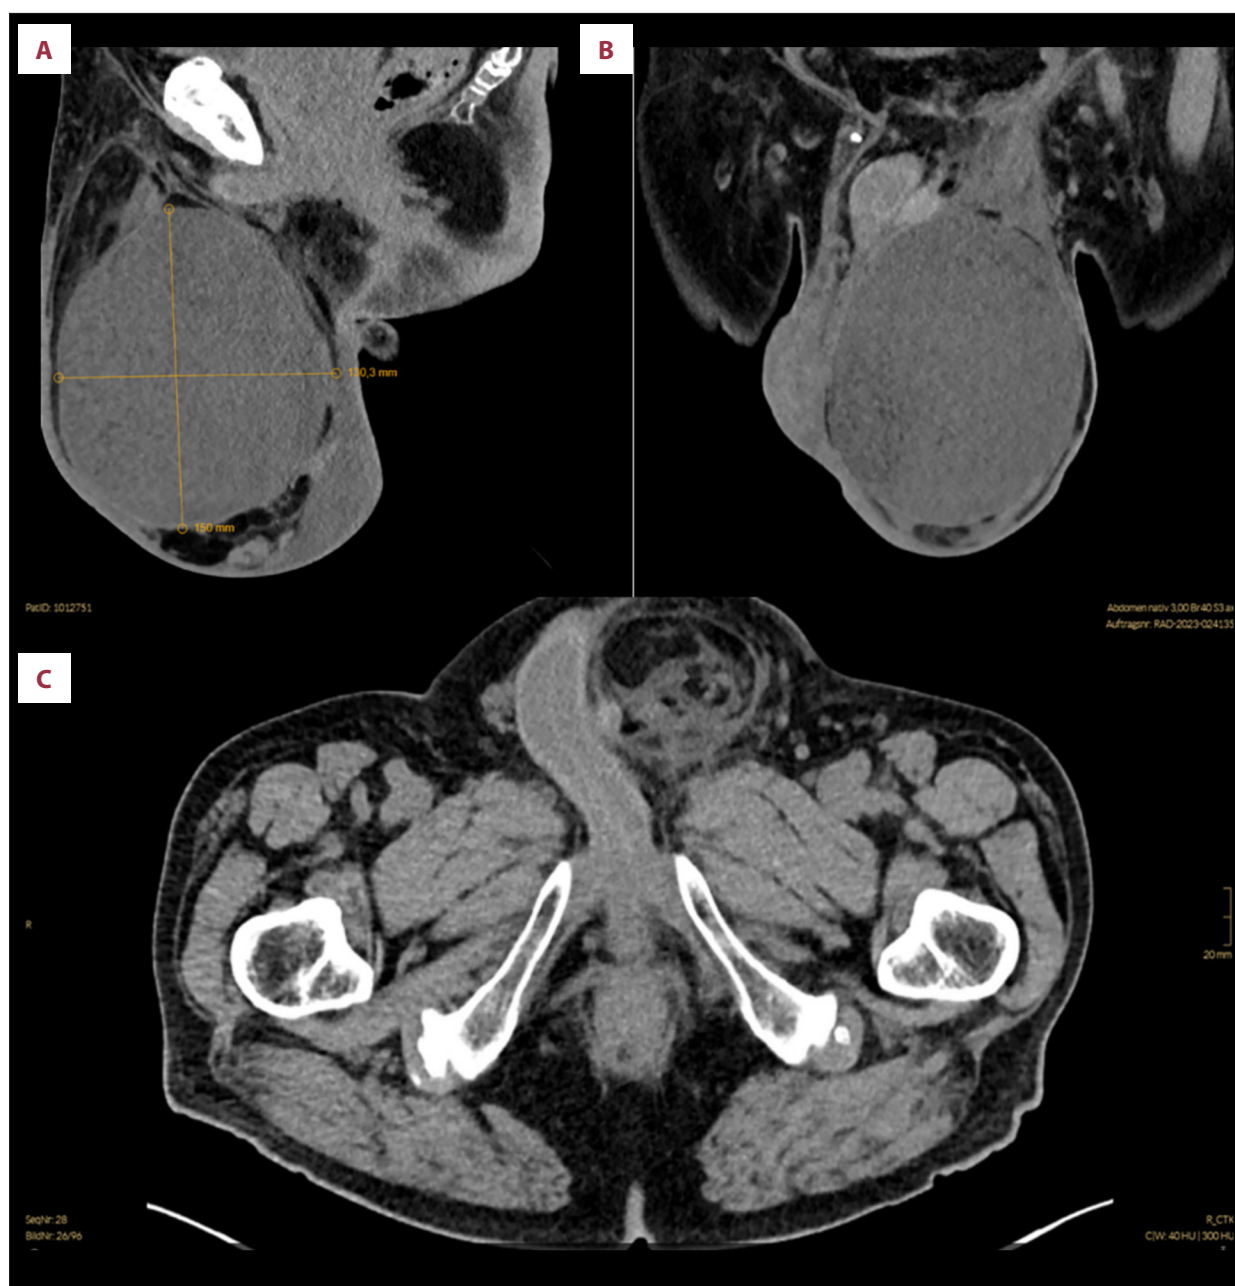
CT scan of the pelvis [A] sagittal; [B] coronal; [C] transversal plane: a well-defined mass measuring approximately 20 × 13 × 12 cm originating from the spermatic cord, surrounded by a hydrocele.
